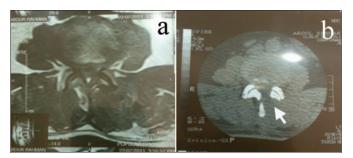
(a) Pre-operative MRI showing LSS, (b) Postoperative CT scan showing Rt. hemilamina dissected out (white arrow).
